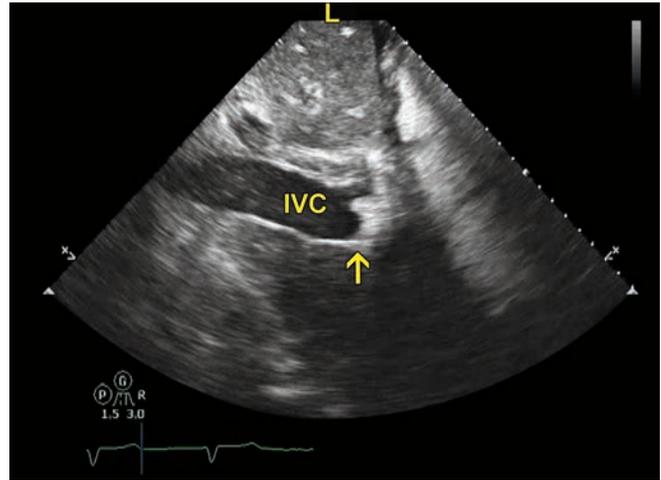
Subcostal/IVC view with ultrasound contrast with delayed filling of the IVC. Arrow shows appearance of bubbles in the IVC.
